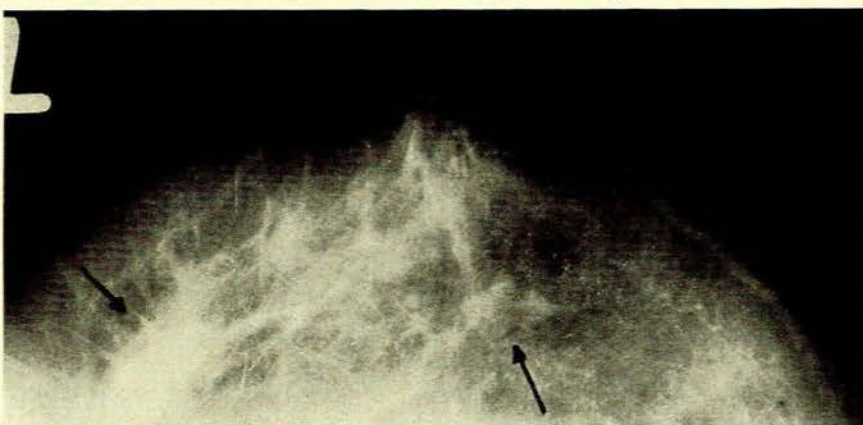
Patient had right mastectomy in June 1968. Left breast gives one an impression of vague parenchymal thickening. X-ray showed two dominant masses: one, in the upper outer quadrant, measured 3.0 x 1.5 cm.; the second, 0.5 cm. in size, was in nipple line 1.0 cm. medially. Both masses were neoplastic.
